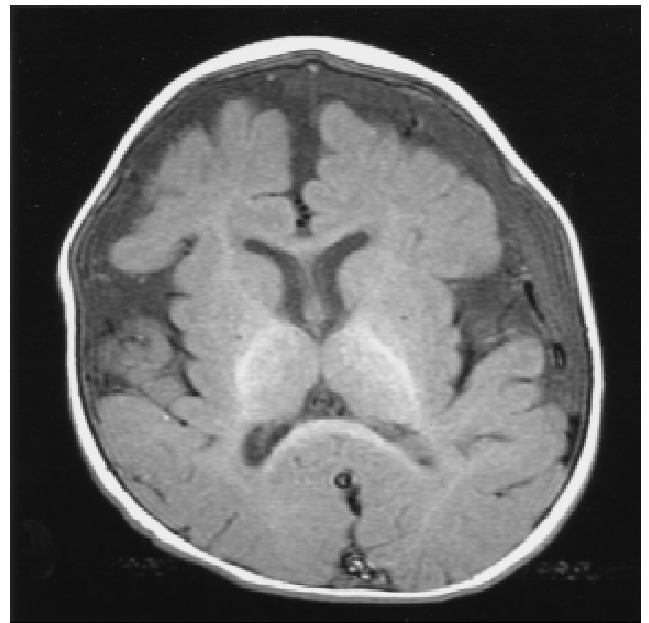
Patient's brain MRI scan at age 6 months. The scan demonstrates brain atrophy and gross dilatation of the extracerebral spaces over both cerebral hemispheres. Fluid is present in the subarachnoid space on the right, with the suggestion that much of the fluid on the left is in the subdural space. No congenital anomalies or delays in myelination are noted.
